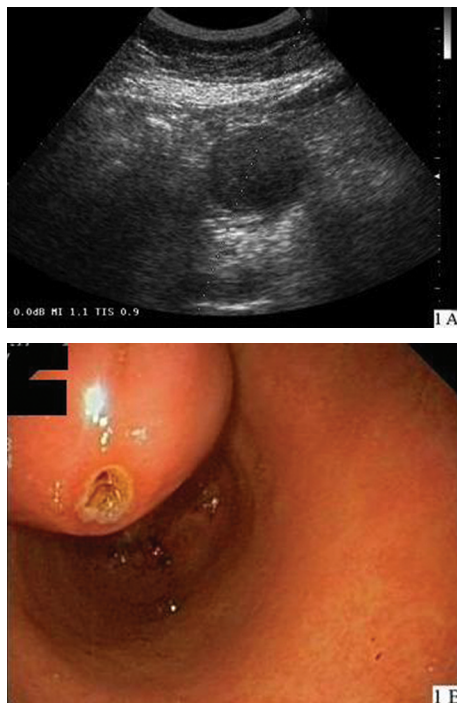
Ultrasonography: A: round, hypoechoic mass on the gastric wall; B: Esophagogastroduodenoscopy: a large antral mass with smooth, normal appearing overlying mucosa and a deep ulceration on the top with flat spots.
